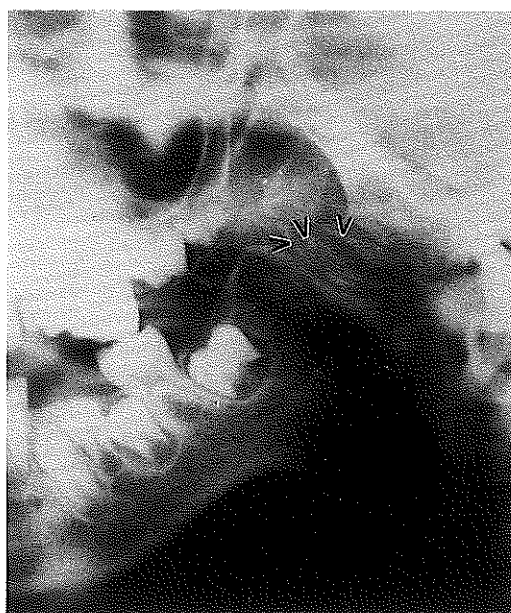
Treatment of ankylosis of the temporomandibular joint using lyo-cartilage. After wide excision of the osseous ankylosis, slices of cartilage (a), loosely tied together with Dexon, are inserted between the stump of the mandible and the base of the skull (b). The calcification and ossification of the slices (c) visible in the X-ray does not lead to renewed ankylosis since the connective tissue ensures permanent separation of the pieces.
